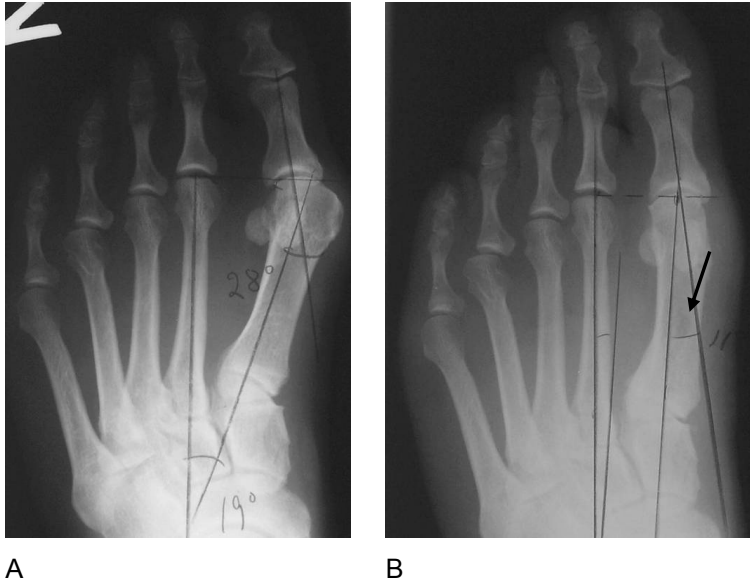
Proximal osteotomy, preoperative (A) and one year postoperative (B) radiographs (arrow = implant channel).
